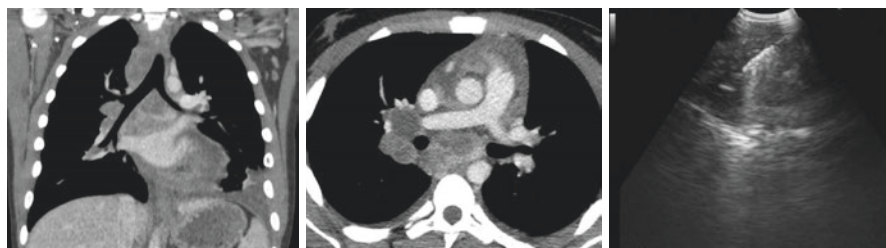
Right and Middle: CT Image showing enlarged 4R and 7 necrotic nodes, Right; endobronchial US view—needling of station 7 node
